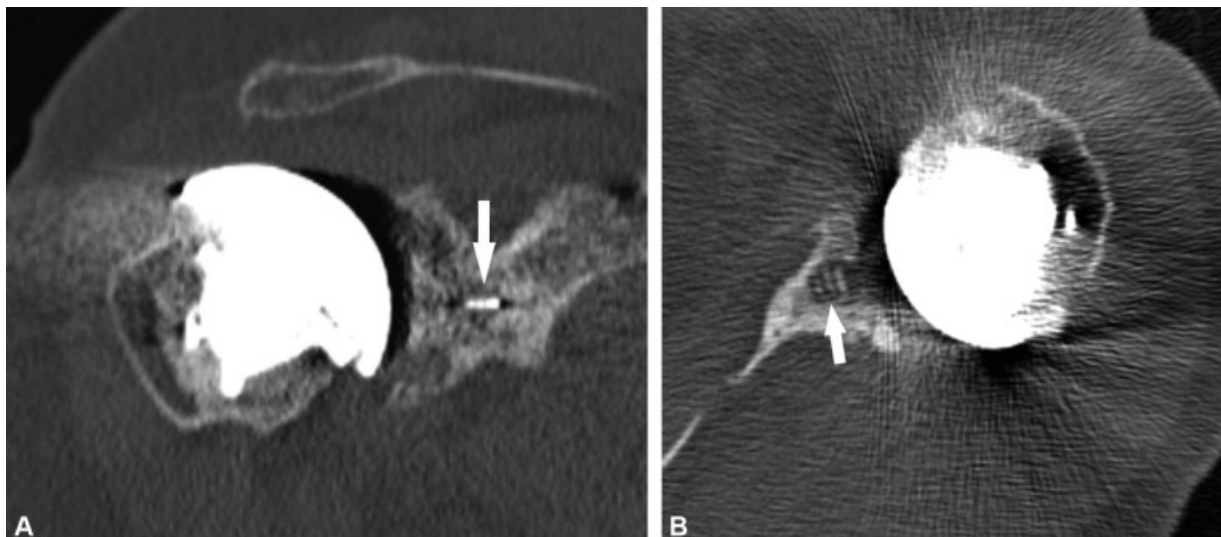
Computed tomography images showing complete osteointegration of the central peg. Note the presence of bone in all spaces between the fins of the central peg (arrows), in coronal (A) and axial (B) views.
